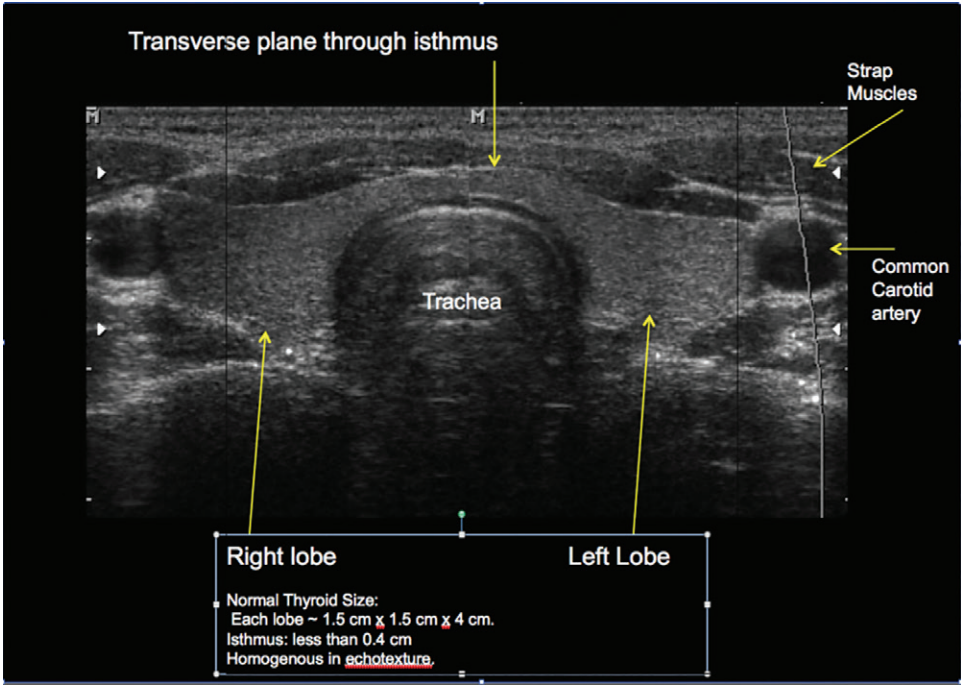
Ultrasound of the thyroid gland
